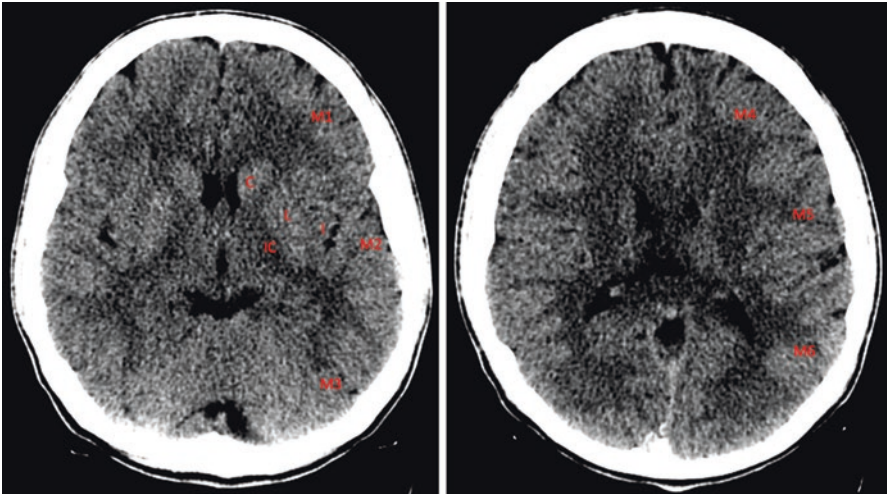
The Alberta Stroke Program Early CT Score (ASPECTS) is a 10-point quantitative CT scan score [71]. Above are two slices from a Head CT (ganglionic and supraganglionic levels) with the regions of the middle cerebral artery (MCA) territory divided into ten parts. *C* caudate, *I* insula, *IC* internal capsule, *L* lentiform nucleus, *M1* anterior MCA cortex, *M2* MCA cortex lateral to insula, *M3* posterior MCA cortex; *M4*, *M5*, *M6* are the anterior, lateral and posterior MCA territories superior to *M1*, *M2*, *M3*
